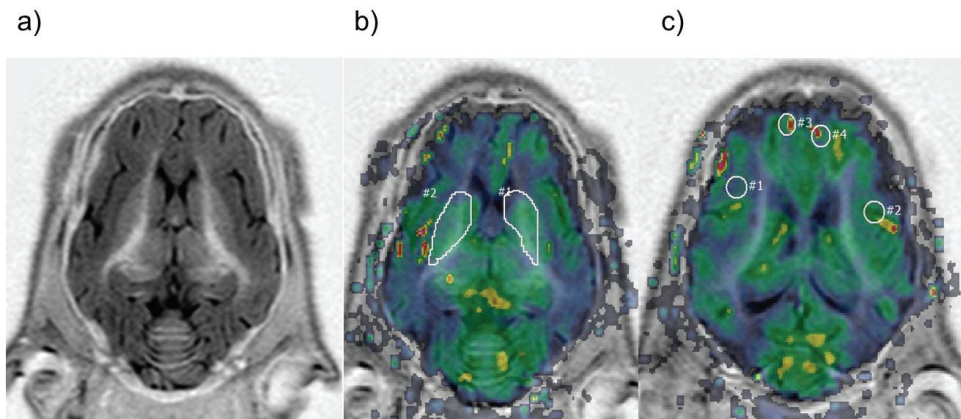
MRI, axial T1 weighted image at baseline a), DSC-MRI CBF map with ROIs around the basal ganglia b), and in the cortex c).
